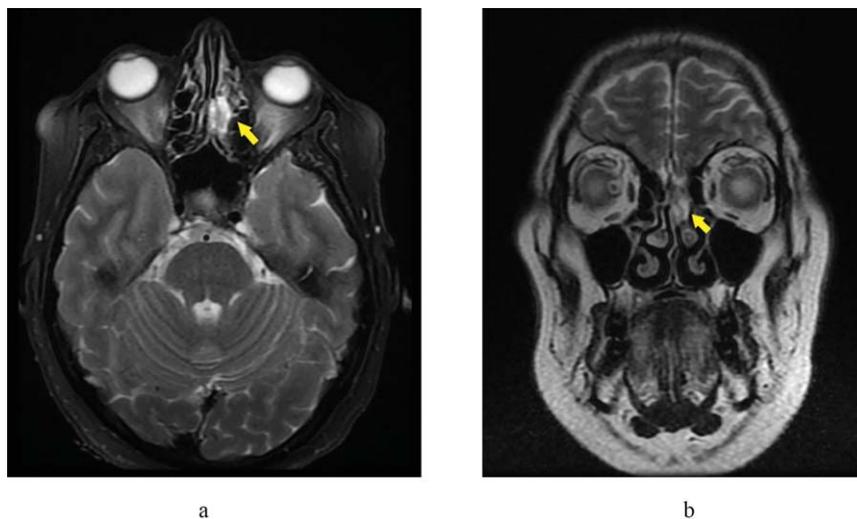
(a) A 7.4 mm defect in the lamina cribrosa is shown in the axial section T2 brain MRI of patient 1. (b) The coronal section T2 brain MRI of patient 1 shows a 7.4 mm defect in the lamina cribrosa.
